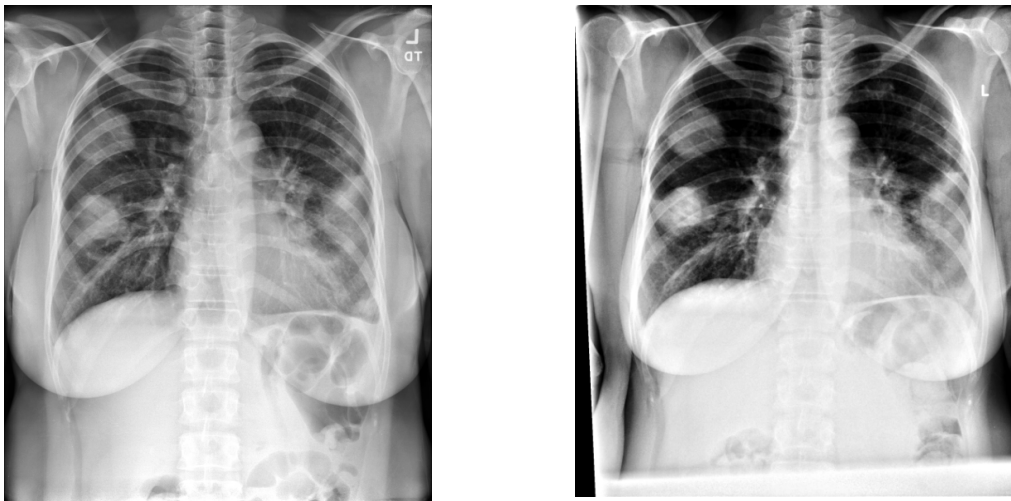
Initial X-ray of chest PA views (left) and repeat X-ray after 6 months (Right)
